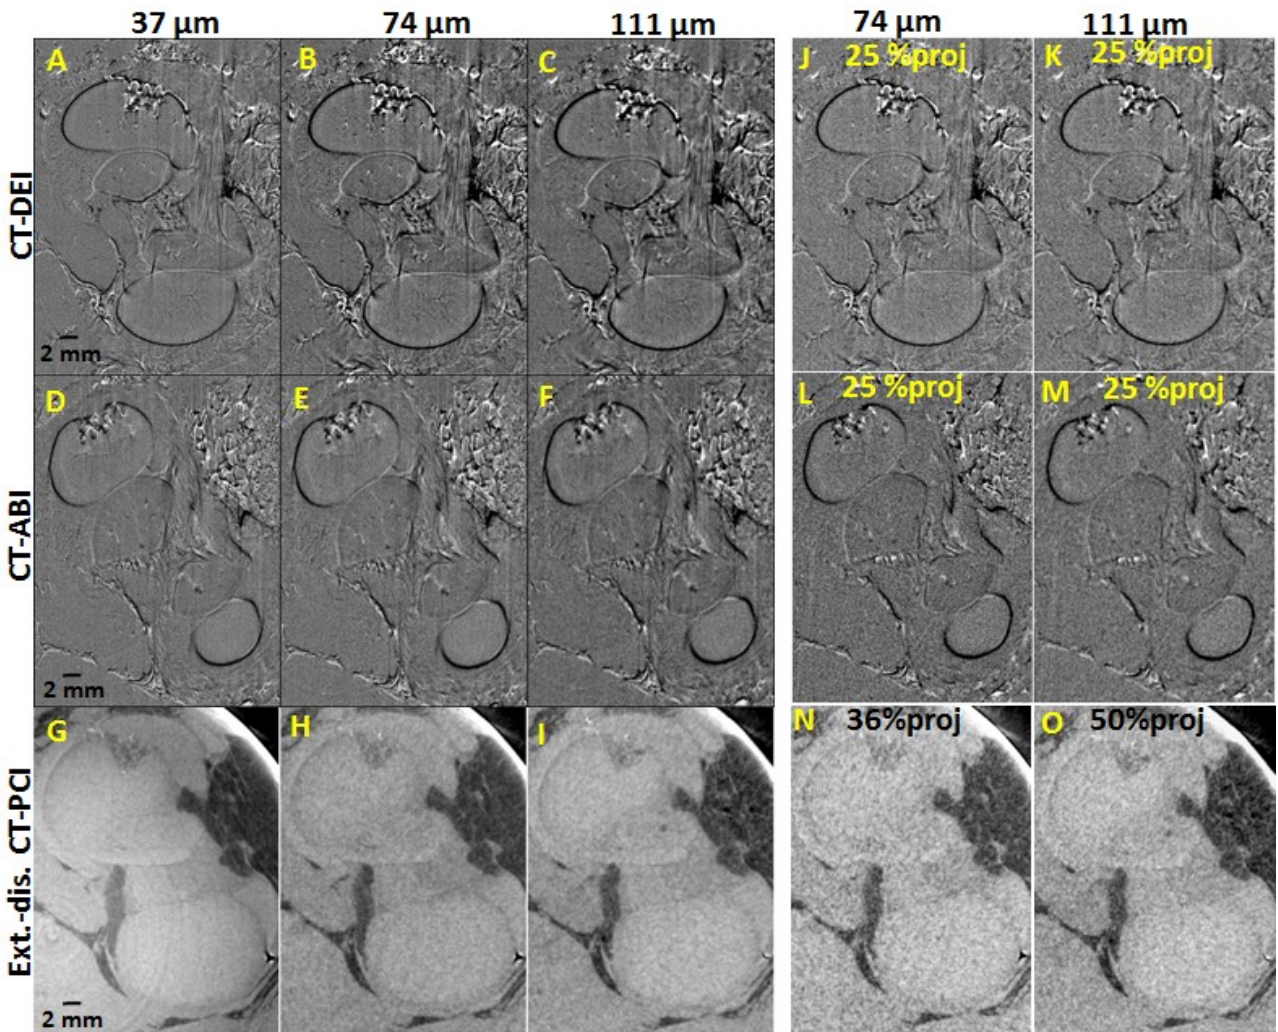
Comparison of representative images from lower resolution CT phase-based imaging. CT-DEI (A–C, J, K), CT-ABI (D–F, L, M), and phase-retrieved extended-distance (ext.-dist.) CT-PCI (G–I, N, O) using 100% (A–I), 25% (J–M), 36% (N), and 50% (O) of standard projections at 37  $\mu\text{m}$  (A, D, G), 74  $\mu\text{m}$  (B, E, H, J, L, N), and 111  $\mu\text{m}$  (C, F, I, K, M, O).
